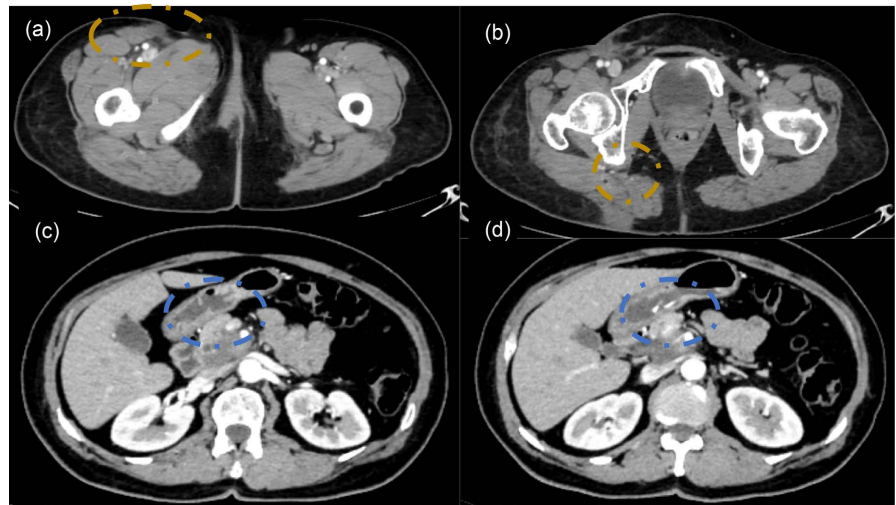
Contrast-enhanced computed tomography (CT) images. (a, b) Axial pelvic CT sections showing a right gluteal subcutaneous soft-tissue lesion at the primary tumor site (yellow dashed circle), raising the differential diagnosis between postoperative fibrotic changes and residual tumor; (c, d) Axial abdominal CT sections demonstrating a conglomerate (“magma”) of enlarged upper mesenteric lymph nodes in the precaval region (blue dashed circle), consistent with metastatic lymphadenopathy in the context of Merkel cell carcinoma.
